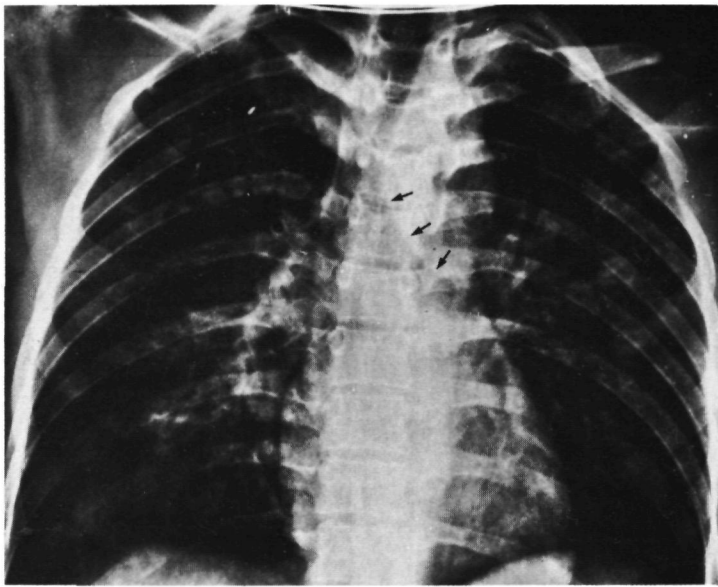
14 Male, 21 years, car-driver. Death due to unrecognised TAR. Diagnosis of TAR at autopsy. Chest X-ray: mediastinal width 7.5 cm. Sharp aortic outline. Only slight displacement of the trachea and left main bronchus (arrows).
